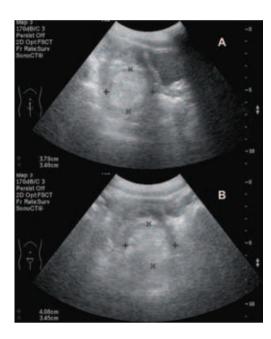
Sonography of the abdomen depicts a homogeneous hyperechoic pelvic mass below the bladder.
